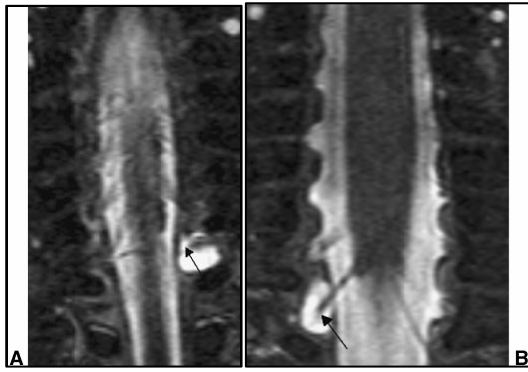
Computed tomography–myelography in an infant of 4 months with obstetric brachial plexus palsy. (A) Myelogram; in a contrast-filled pseudomeningocele (arrow), root shadows are demonstrated. Intact anterior and posterior roots (double arrow) on the non involved side. (B) Computer tomography–myelography; no recognizable root shadows in the contrast-filled pseudomeningocele (arrow). Intact roots on the non involved side (double arrow)
